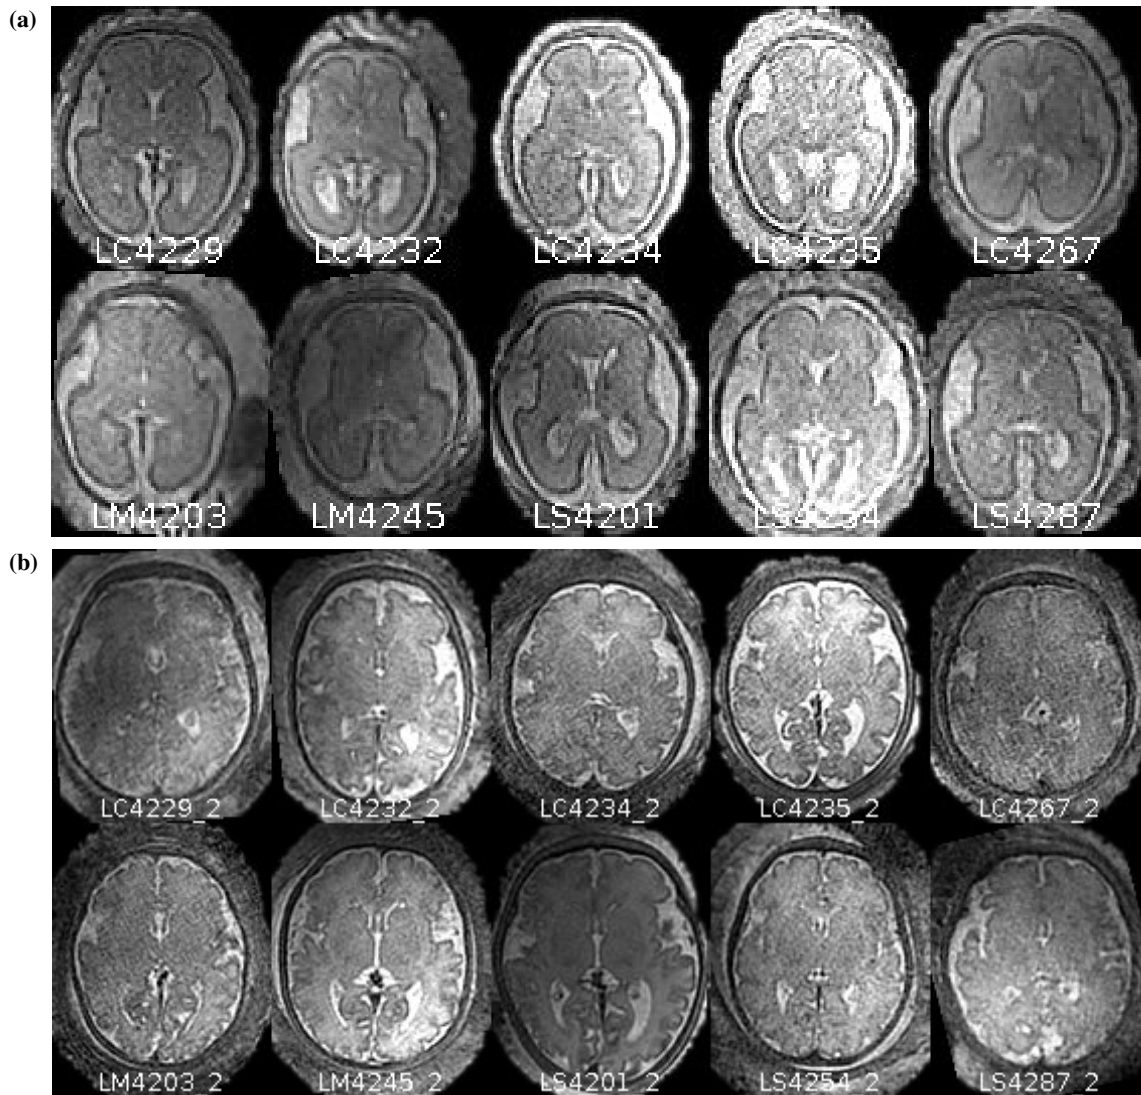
After being motion corrected using SLIMMER tool, quality of fetal brain MR images is improved. (a) Central slices in the transverse view of ten fetal brain images in the second trimester of GA; (b) paired ten fetal brain central slice images in the third trimester of GA.
